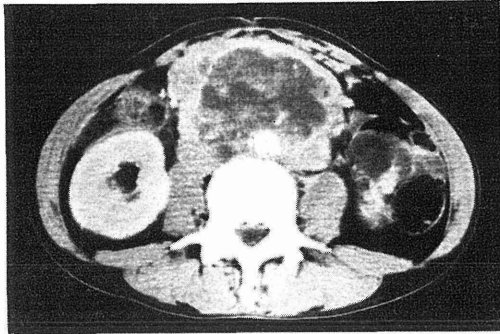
Abdominal CT before chemotherapy.
